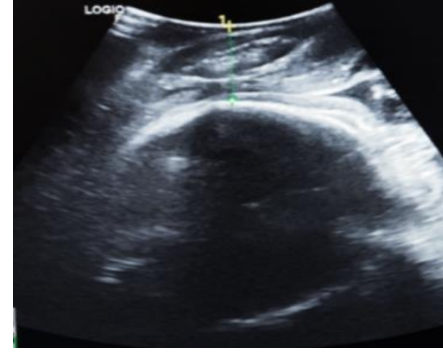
Transperineal Ultrasound. Measurement of Head-Perineum Distance
